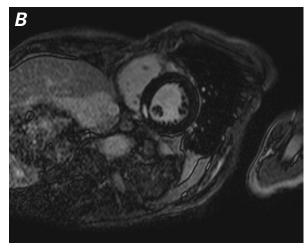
Cardiac magnetic resonance image (short-axis view) of the left ventricle shows delayed gadolinium enhancement of the A) basal and B) mid inferoseptum.
